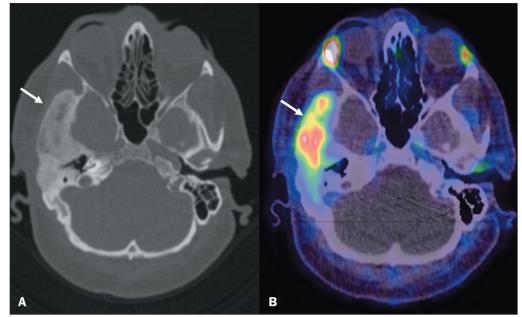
Preoperative ⁶⁸Ga-PSMA PET/CT of a 58-year-old male patient, performed for the staging of prostate cancer. CT scan (A) showing increased bone thickness with homogeneous ground-glass opacity and loss of the normal trabecular pattern, suggestive of fibrous dysplasia, in the right temporal bone (arrow). Note the PSMA uptake (arrow) in B (SUVmax, 5.9).
